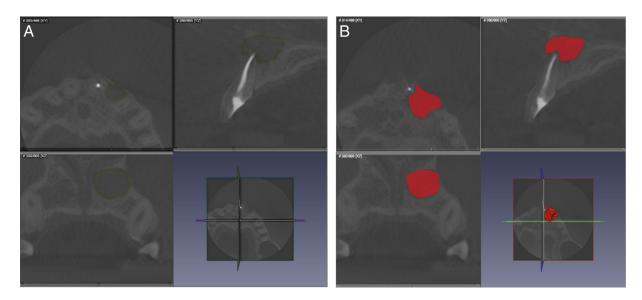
A segmentation procedure with the use of specialized software. (*A*) Tracing of periapical lesion borders in all 3 CBCT planes with the use of a lasso tool. (*B*) 3D reconstruction of the radiolucency with the use of an interpolation feature. The software calculates volume and density at the end of the segmentation process.
